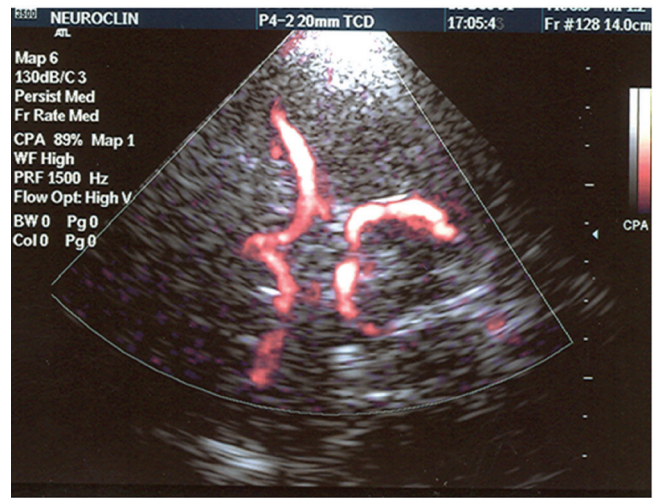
Transcranial color coded Doppler (TCCD): Circle of Willis. Color coded blood flow velocities in “Power Doppler” mode indirectly depicts the vessels.
